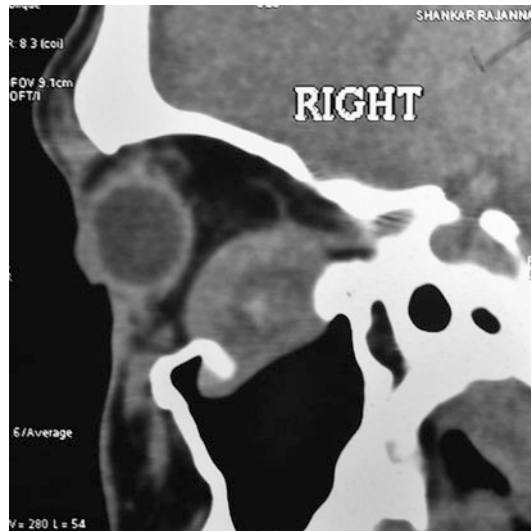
Sagittal reconstructed CT scan of the same patient showing the posterior extent of the mass
